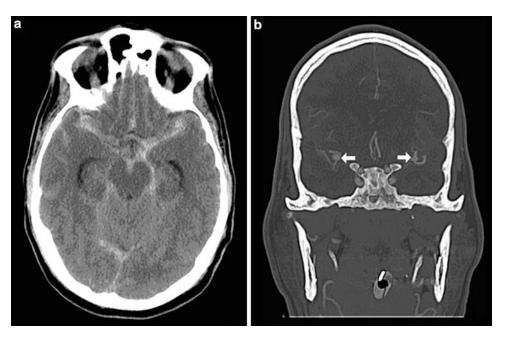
(a) Noncontrast head CT demonstrates diffuse subarachnoid hemorrhage throughout the basal cisterns and bilateral Sylvian fissures, from a ruptured intracranial
